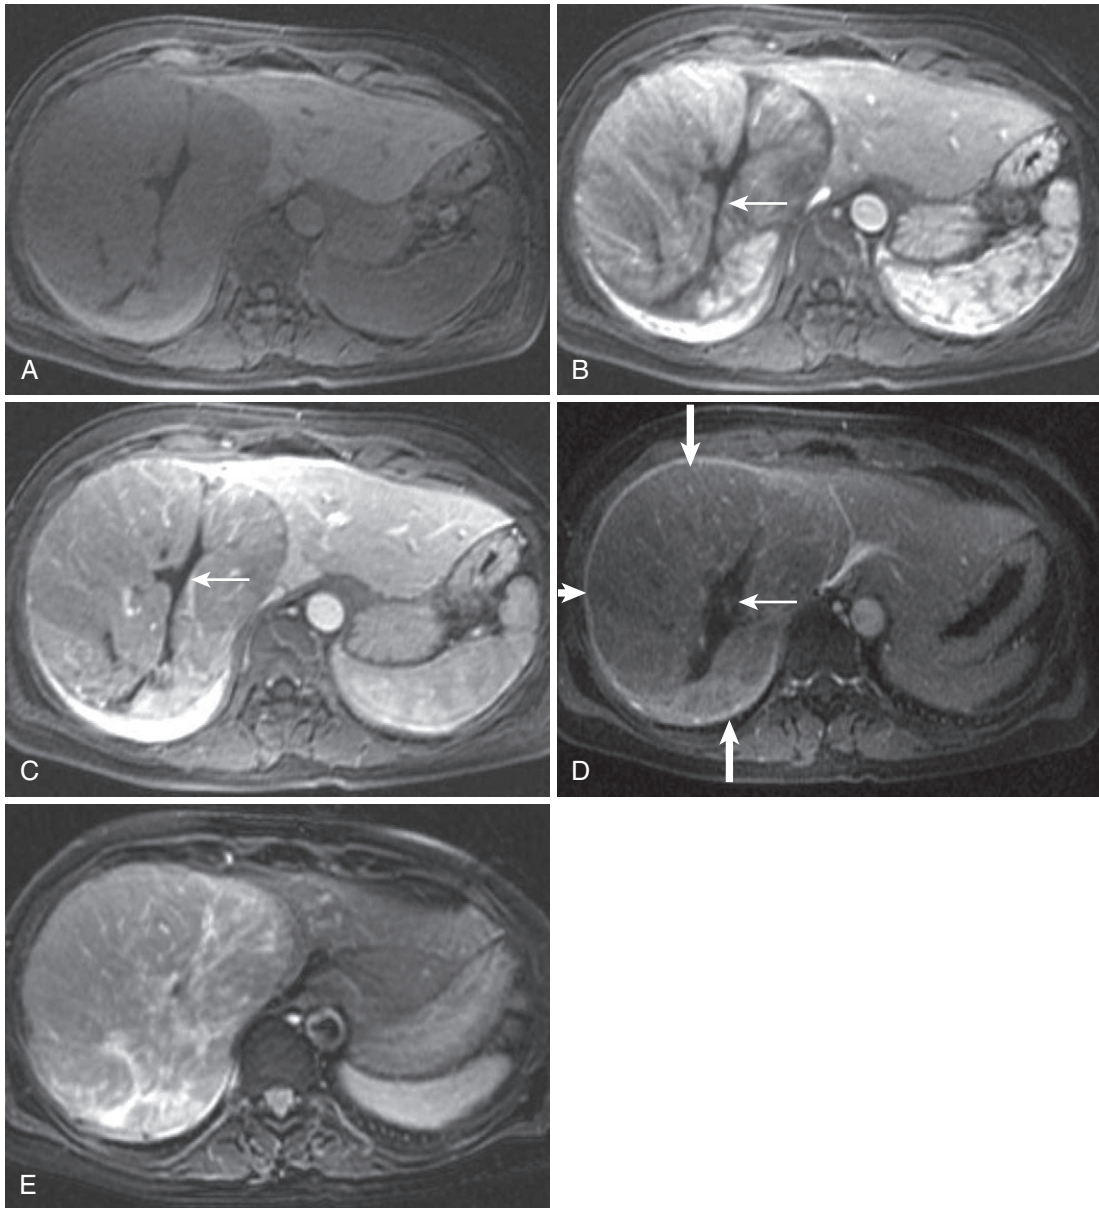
Fibrolamellar HCC. The large hypervascular mass has a central hypointense scar on the precontrast image (A), enhances on the arterial phase image (B) with the exception of the central scar (*thin arrow* in B-D). Washout is progressively evident on the portal phase image (C) compared with the delayed image (D), as is the late-enhancing capsule (*thick arrows* in D). E, Hyperintensity is evident on the moderately T2-weighted image. Note the lack of cirrhotic features.
